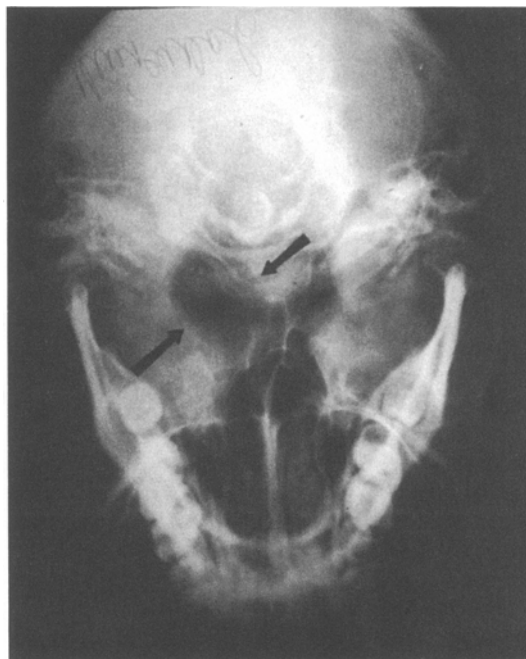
Plain skull X-Rays demonstrate erosion of the floor of the middle fossa and widening of the foramen ovale
